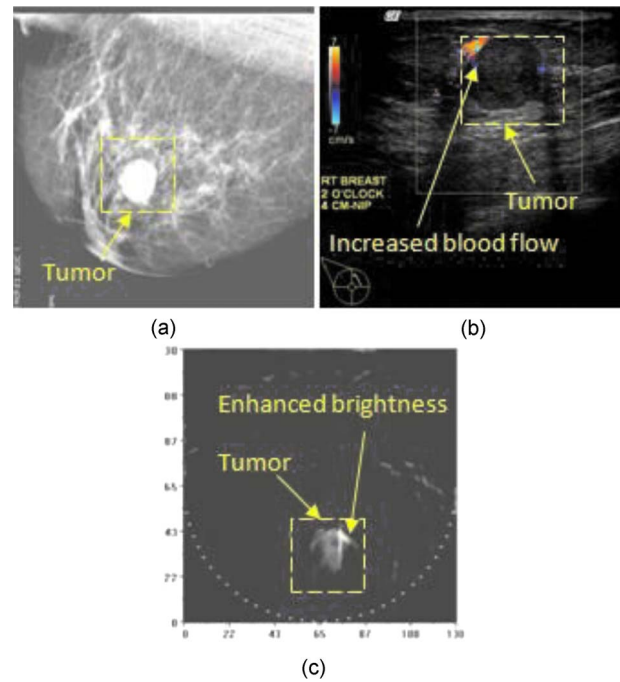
(a) Digital mammography image (mediolateral projection) of the breast, showing a round, apparently benign tumor. (b) Ultrasonic imaging with the Doppler showing the tumor boundaries and the focal blood flow increase. (c) Optoacoustic image (mediolateral projection) showing the enhanced contrast around the area of the focal blood flow increase detected by the Doppler ultrasound.
